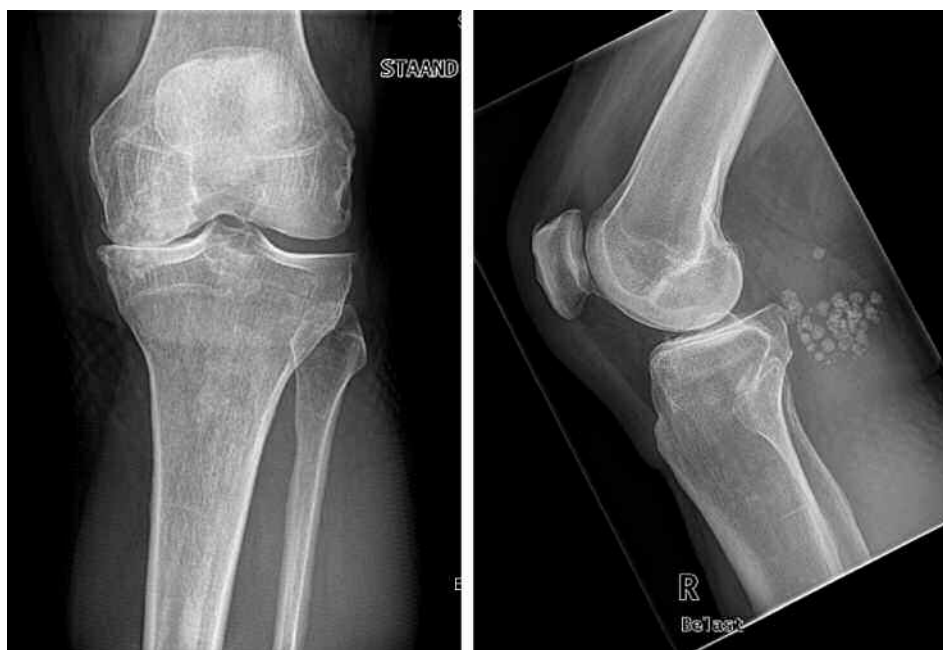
Radiography reveals multiple round or ovoid ossified loose bodies dorsally to the right knee joint and signs of osteoarthritis.
